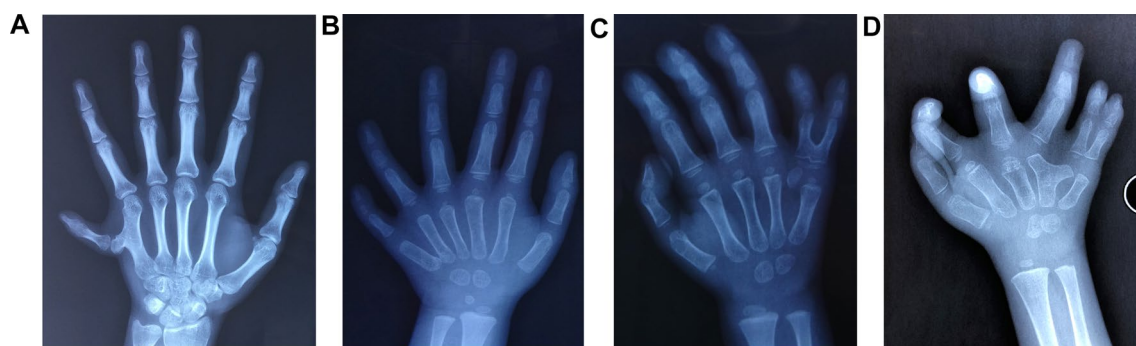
Radiographic examples of Type 4 ulnar polydactyly. (A) X-ray of a Type 4a case, showing a bifid fifth metacarpal. (B) X-ray of a Type 4b case, showing a fully duplicated fifth metacarpal. (C) X-ray of a Type 4c case, showing a hypoplastic, duplicated fifth metacarpal. Note the fusion between the proximal phalanges of the fifth and supernumerary digits. (D) X-ray of a Type 4d case, showing a duplication of the little finger originating from the bifid fourth metacarpal
